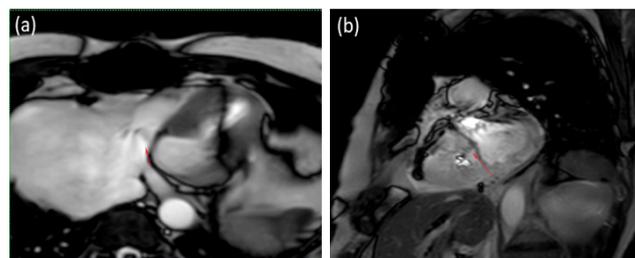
(a): Cardiac MRI showing trans-septal scar (red arrow) (b): leading to isolated tricuspid regurgitation due to tethering of posterior tricuspid leaflet.
